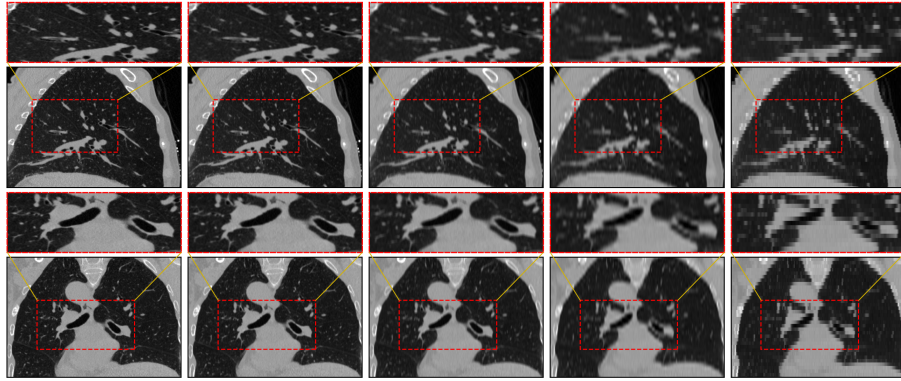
Qualitative comparison of through-plane CT SR. Matched coronal and sagittal views (ordered by fidelity: 1 mm HR, TVSRN-V2, TVSRN, bicubic, 5 mm LR). Red crops highlight lobar/proximal bronchi and adjacent bronchovascular structures. TVSRN-V2 preserves airway continuity and anatomical boundaries better than baselines, without generating spurious structures.
